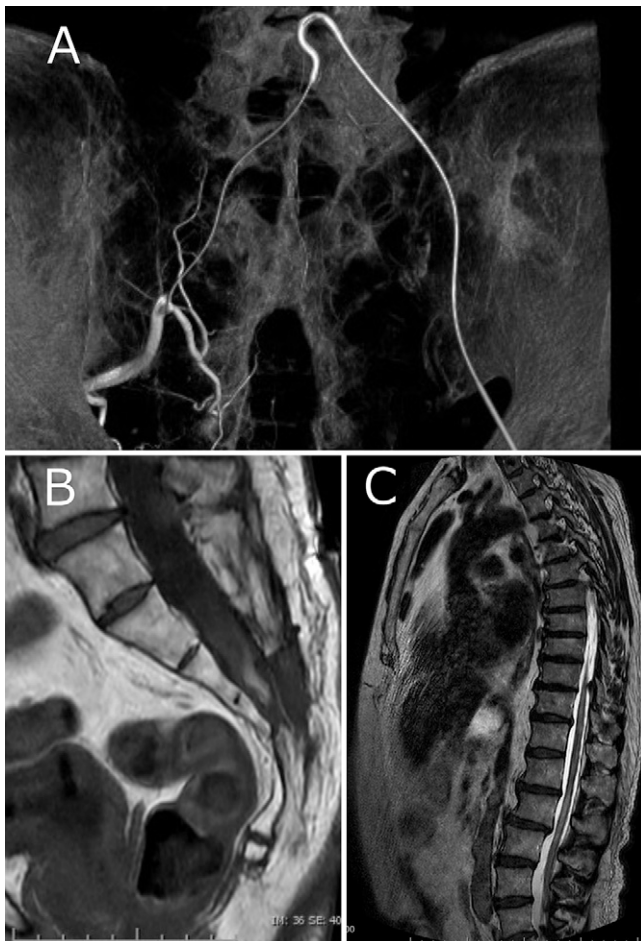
Postoperative digital subtraction angiography showed disappearance of abnormal vessels (A). T2-weighted MRI showing improvement in spinal cord edema (B). MRI showing absence of the FTL (C).
